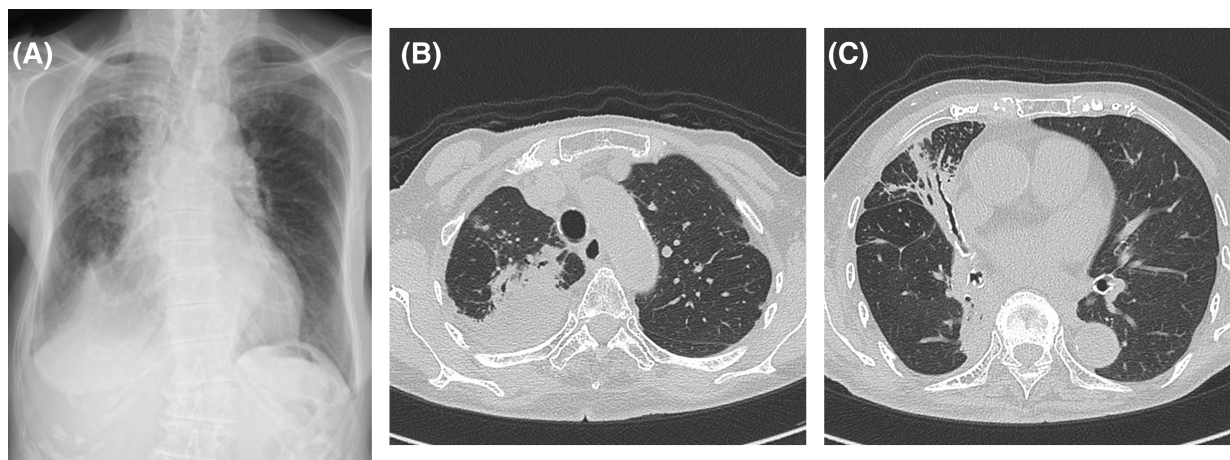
Chest x-ray shows opacities in the right lung and slight right pleural effusion (A). Chest computed tomography showed a consolidation on the mediastinal side of the right lung following radiotherapy (B) and nodules with bronchiectasis of the right upper and middle lobe (C).
